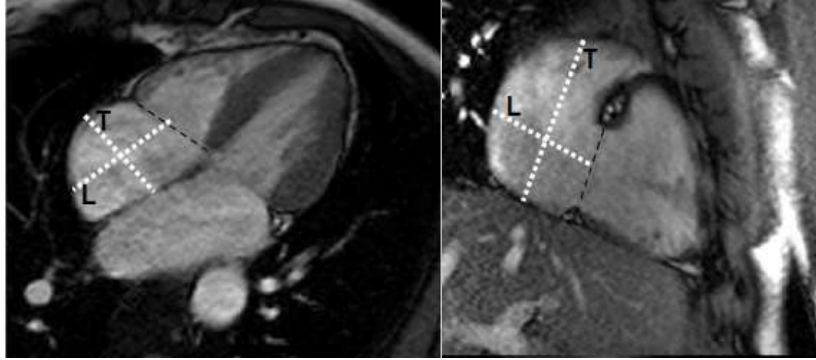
Linear dimension of RA. Left: apical 4-chamber view. Right: apical right 2-chamber view. L: longitudinal diameter; T: transverse diameter. Image source [69].
